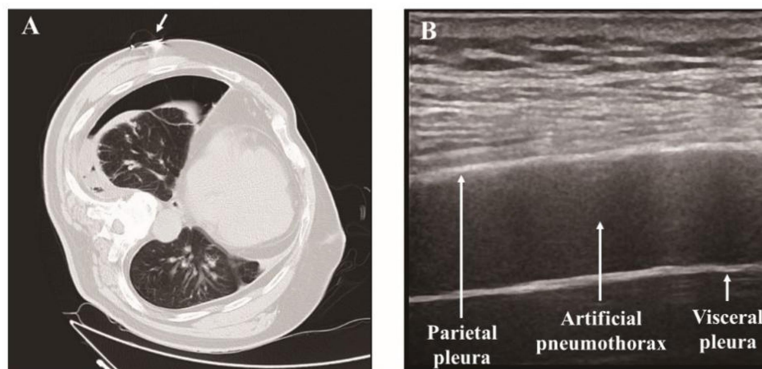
Thoracic CT and ultrasound images of an artificial pneumothorax. (A) Artificial pneumothorax image in a lateral decubitus position CT scan. White arrow indicated the pleural access point marked by a clip. (B) Artificial pneumothorax image in thoracic ultrasound.
